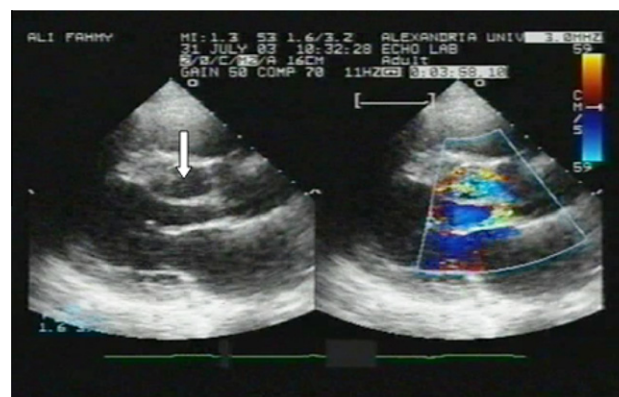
Parasternal long-axis view shows aneurysmal cavity (arrow) arising from right sinus of Valsalva. In same view, color Doppler shows flow from ruptured right sinus of Valsalva into aneurysmal cavity. Mild aortic regurgitant jet is noted.
